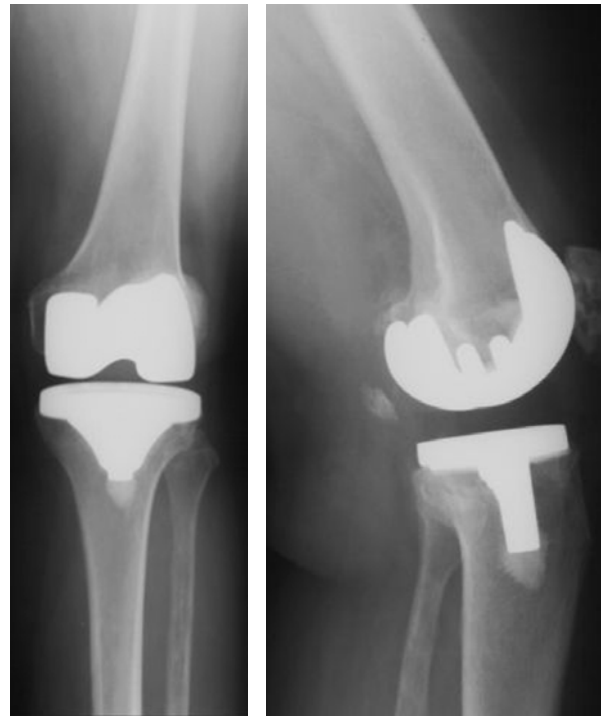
Anteroposterior (A) and lateral (B) radiographs of the knee of a 55 year old woman who received a cruciate-retaining prosthesis.
